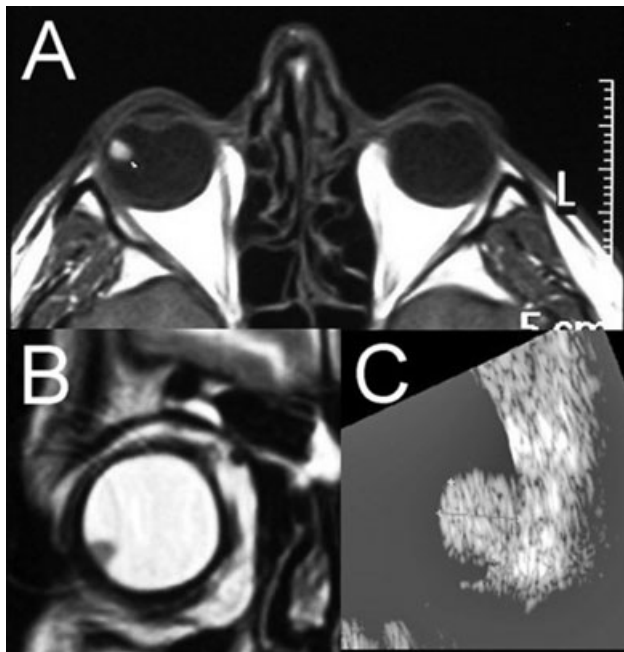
A: Axial cranio-orbital T1-weighted MRI scan showing the hyper-intense tumour. B: The tumour is hypo-intense on coronal T2-weighted view. C: B-mode ultrasonogram demonstrating the dimensions of tumour.
